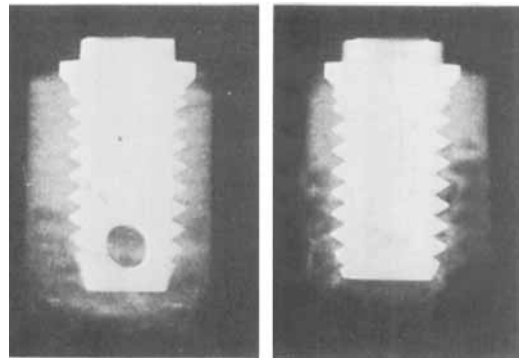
X-rays of removed tibial fixtures. An X-ray alone does not give conclusive evidence of osseointegration due to the poor resolution level.
